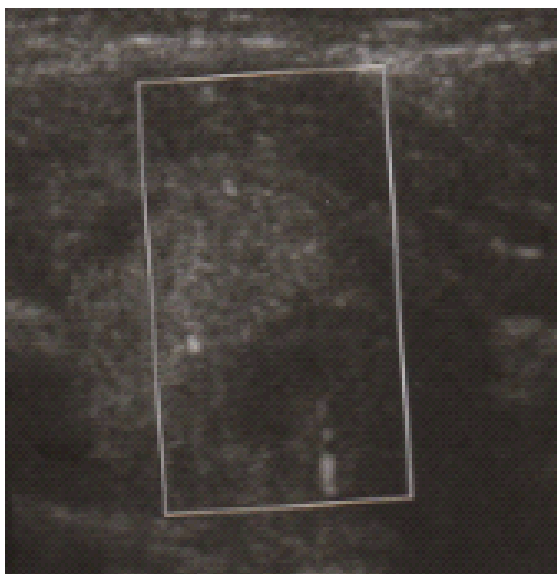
Case 1: thyroid ultrasound (longitudinal section: macronodules with peri and intra-nodular vascularization)
